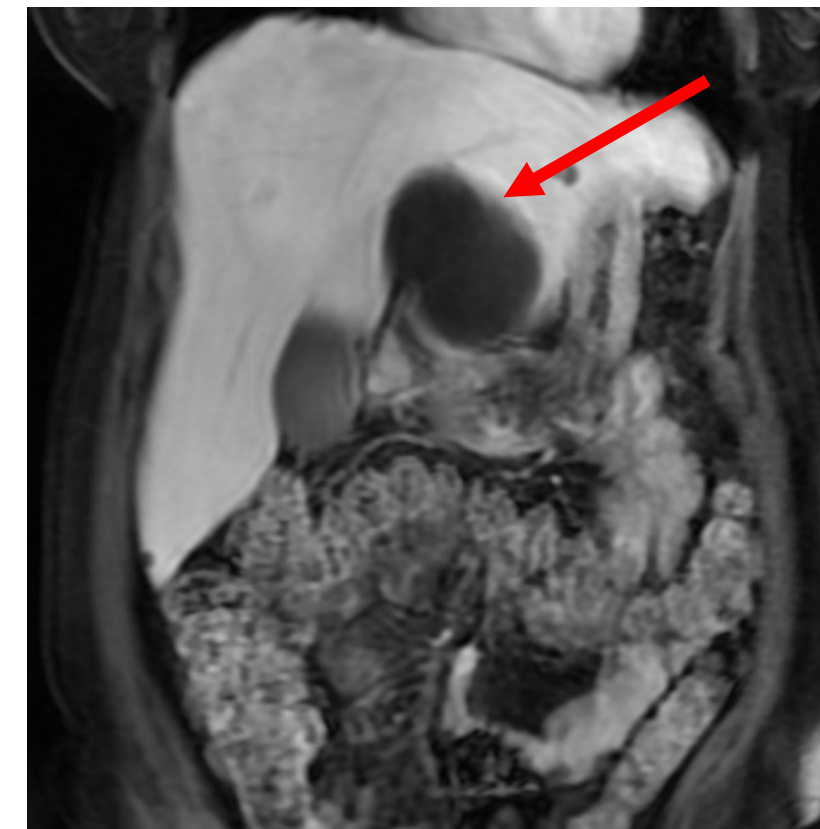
MRI Liver showing hepatic cyst prior to endoscopic ablation
